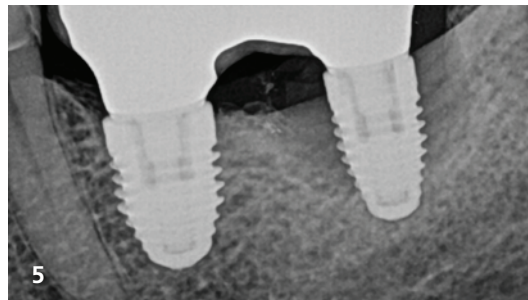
Clinical reevaluation prior to surgical intervention. Fig. 5: Preoperative radiograph conducted before surgery. Fig. 6: Fixed prosthesis removed to facilitate access to the surgical site. Fig. 7: GalvoSurge® spray head equipped with a sponge to maintain maximum contact of the cleaning solution with the implant surface.
